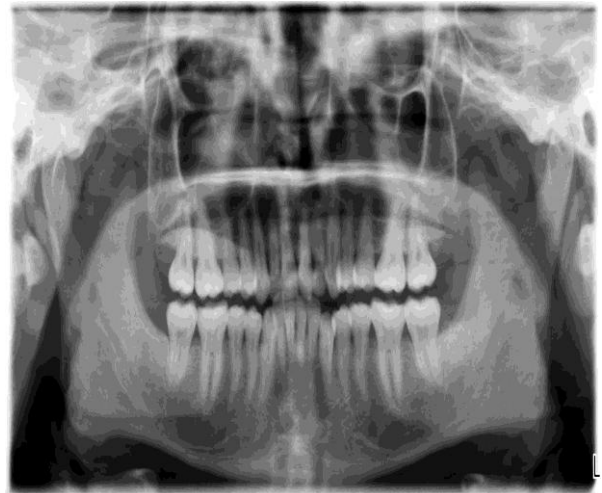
Sequential radiographic findings of the socket
